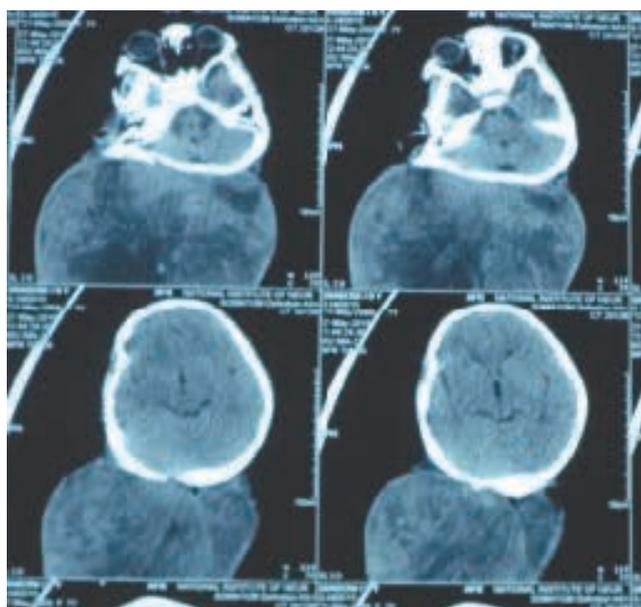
CT scan Brain showed large mass lesion with central hypodence area
